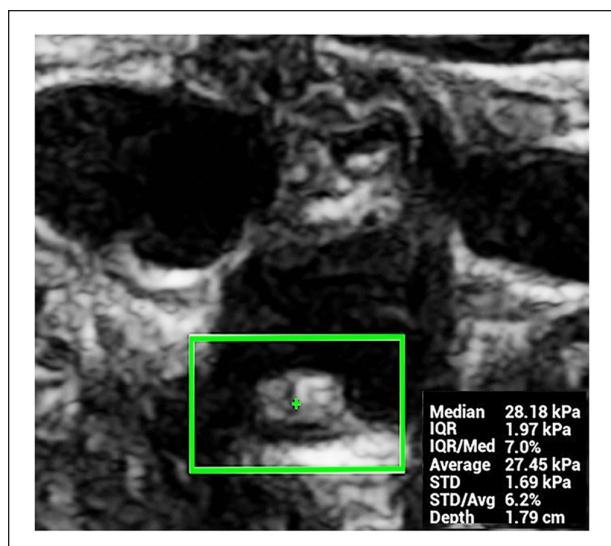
An example image of point shear wave ultrasound. A transverse pSWE image demonstrates placement of the data acquisition point within a focal carotid plaque (green cross) and display of quantitative metrics (lower right corner of image).
